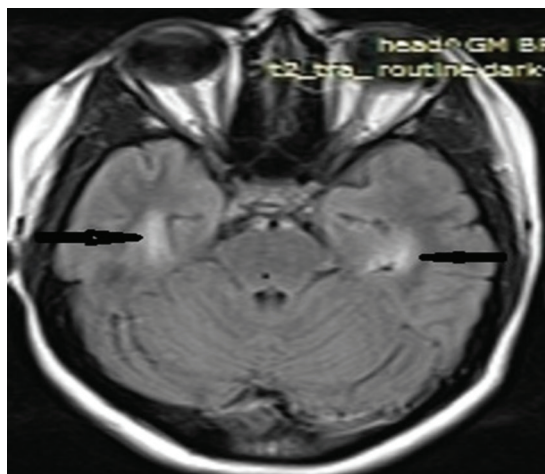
MRI (magnetic resonance imaging) brain FLAIR (fluid attenuation inversion recovery) sequence before treatment showing bilateral hyperintensity in the medial temporal regions (black arrows), suggesting encephalitis.
